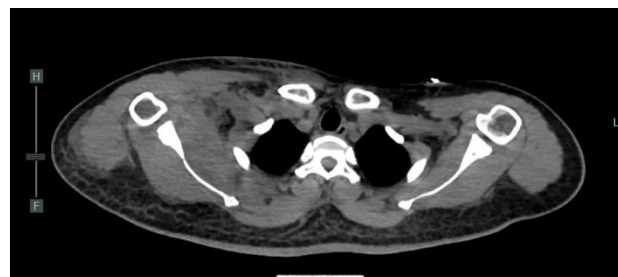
CT Thorax axial view
